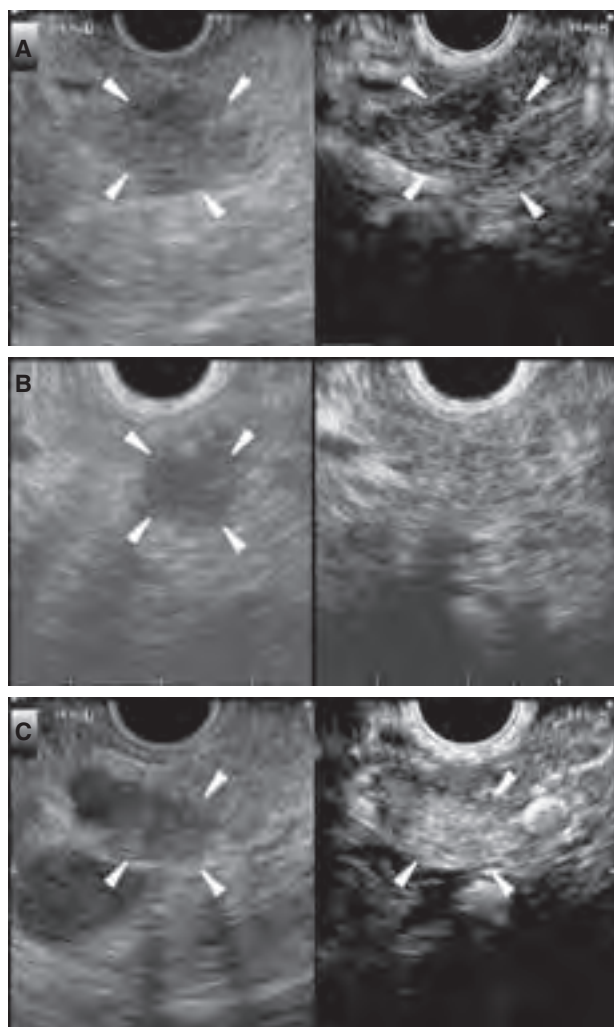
Typical contrast-enhanced harmonic endoscopic ultrasound (CH-EUS) images of pancreatic tumors. (a) Ductal carcinoma with hypoechoic enhancement. Conventional EUS (left) shows a hypoechoic area (arrowheads) of 15 mm in diameter at the pancreas tail. CH-EUS (right) indicates that the area has hypoechoic enhancement (arrowheads) compared with the surrounding tissue. (b) Inflammatory pseudotumor with isoechoic enhancement. Conventional EUS (left) shows a hypoechoic area (arrowheads) of 9 mm at the pancreas body. CH-EUS (right) indicates homogeneous enhancement in this area similar to the surrounding tissue; a margin is not observed. (c) Neuroendocrine tumor with hyperechoic enhancement. Conventional EUS (left) shows a hyperechoic mass (arrowheads) of 9 mm in diameter at the pancreas body. CH-EUS (right) indicates that enhancement (arrowheads) in the mass is higher than in the surrounding tissue.
